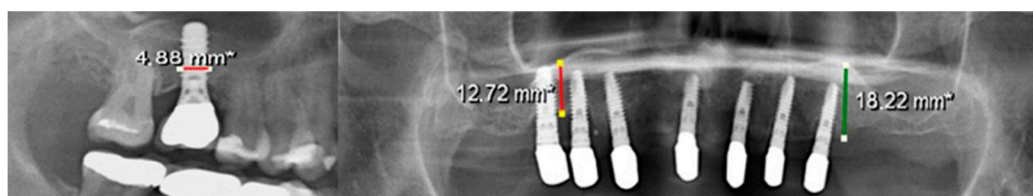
Calibration of the panoramic X-ray for accurate measurement of the bone resorption.
